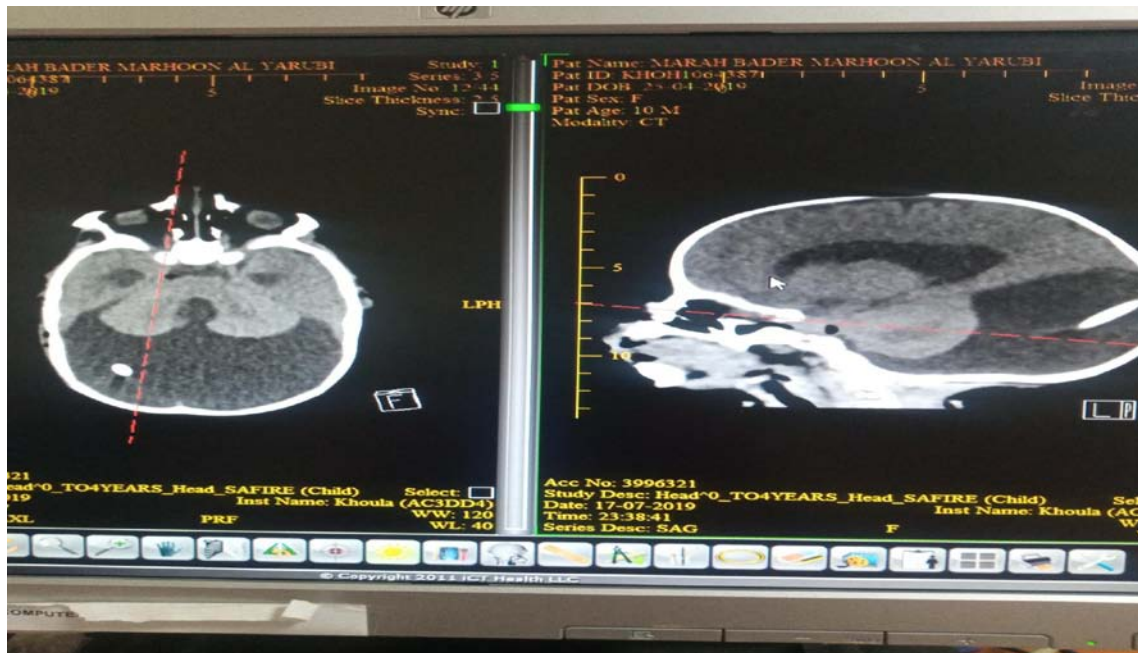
CT showing new shunt placement after endoscopic removal of migrated shunt
